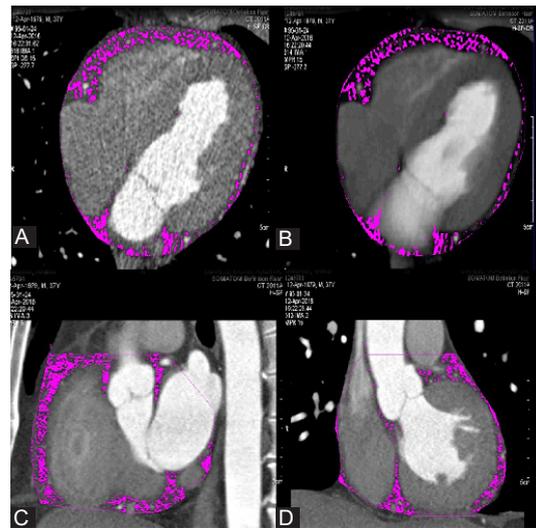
CT Volumetric Measurement of EFT in Transaxial View (A,B), Sagittal View (C) Coronal View(D) With Contrast Enhancement.
